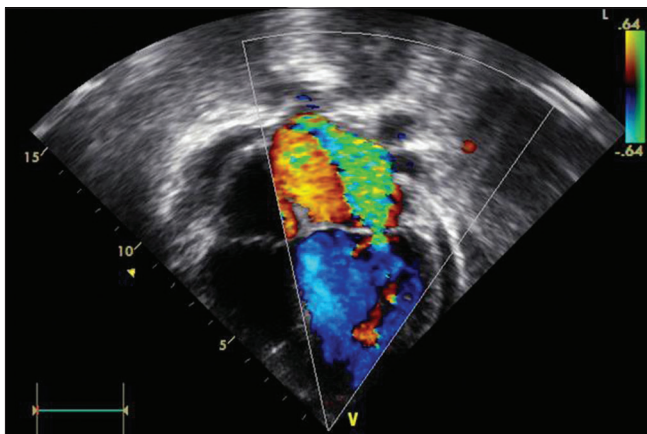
Echocardiography showing second-degree mitral regurgitation and pericardial effusion of 10 mm around left ventricle
